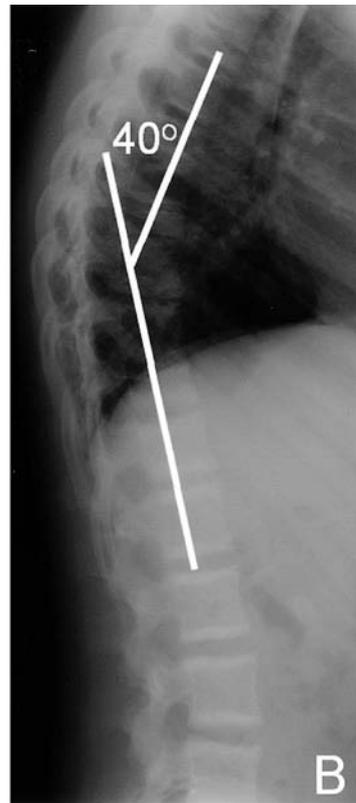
Patient 1: lateral spinal radiographs show improvement of kyphosis from start of pamidronate therapy (A) and at last followup 3 years later (B).
